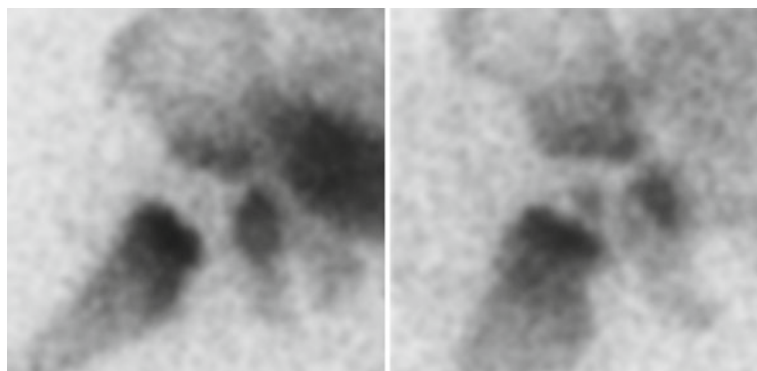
An 11-year-old male with low back pain for several months. Relieved by Advil. X-ray suggested scoliosis. New plain x-rays suggested sclerosis of pedicle of L5.
